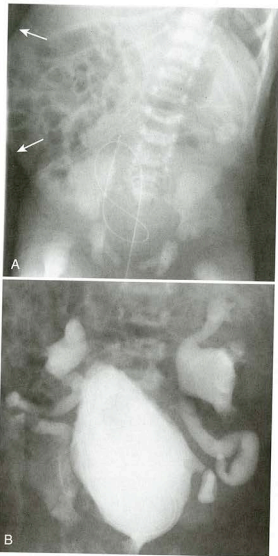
Prune belly syndrome. A, Radiograph shows bulging flanks (arrows). B, VCUG shows bilateral grade 5 VUR and trabeculated bladder.
